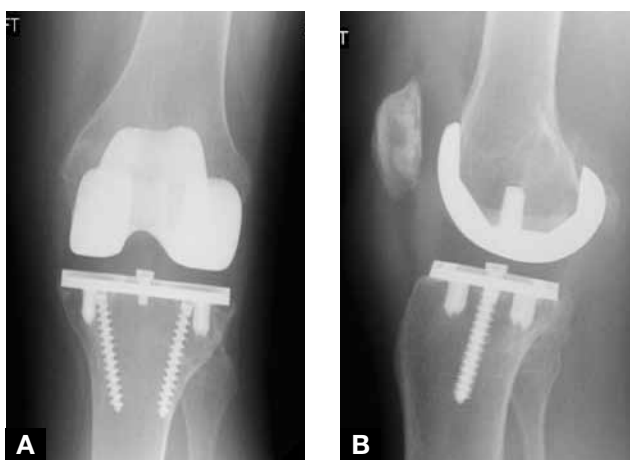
(A, B) At 22 years, radiographs of Natural-Knee I (NK-I) system with cementless fixation of femoral component and resurfacing tibial baseplate.
